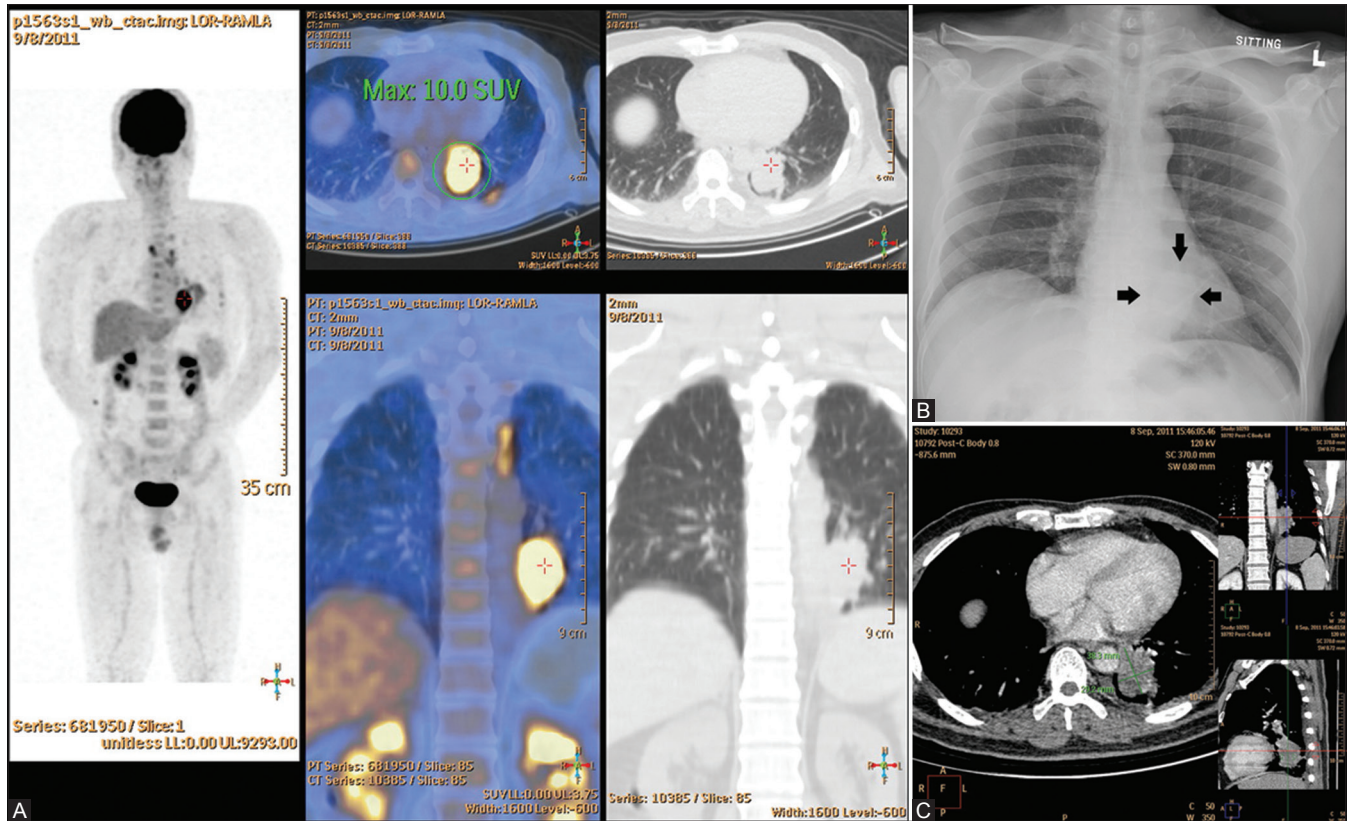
(A–C): (A) Axial and coronal images of fusion PET/CT showing a hypermetabolic (SUVmax: 10.0) left lower lobe mass suspicious of lung cancer with mediastinal nodal metastases. (B) Frontal chest radiograph of the same patient, showing a retrocardiac mass (arrows). (C) Axial, coronal, and sagittal CT images of the same patient confirming an irregular soft tissue lung mass at the retrocardiac region
